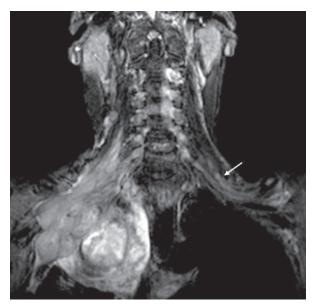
In an another case MRI shows a large heterogenous lesion is seen in the apex of right lung involving the ribs, brachial plexus and adjacent soft tissues. Brachial plexus is normal on left side (arrow)
